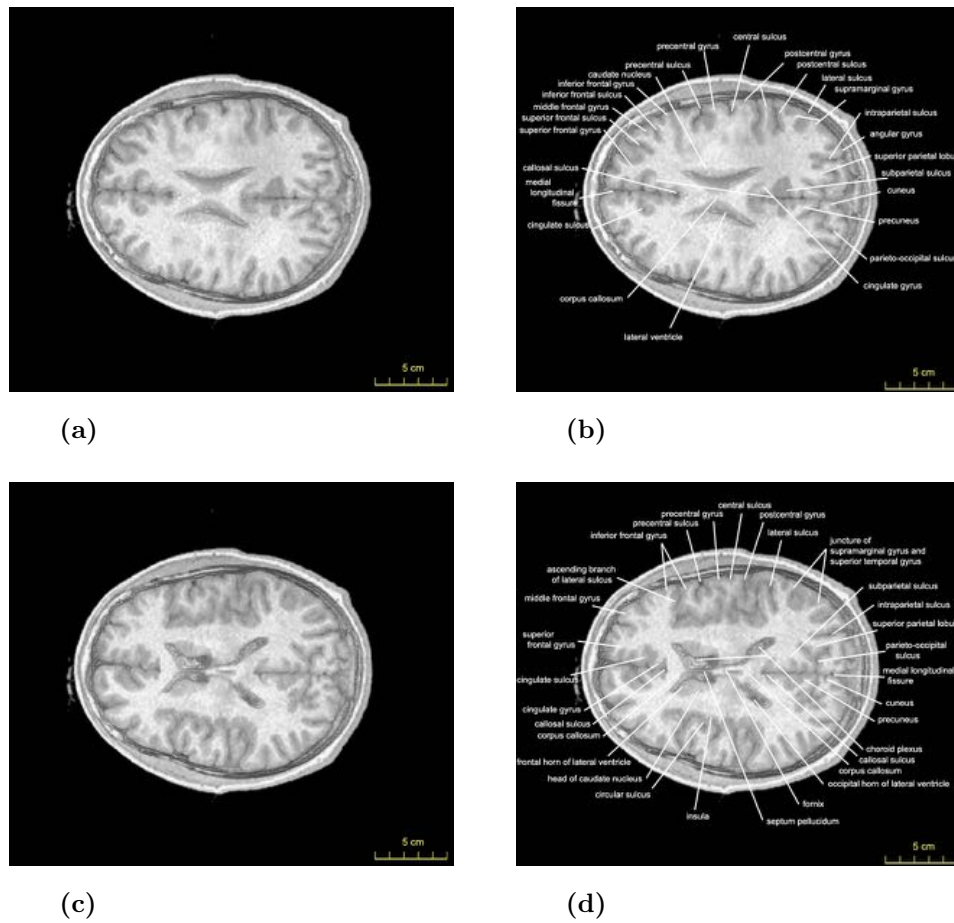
Labelled Brain MRI Slices described as reference for radiologists ([Michigan State University 2014](#)).
